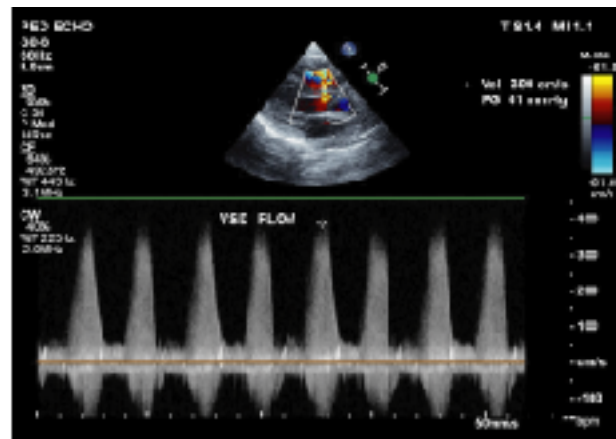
Doppler Echocardiography shows VSD flow.
